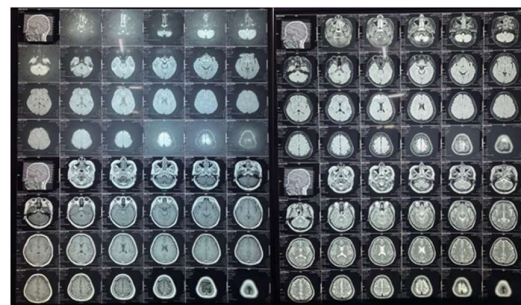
MRI Examination
